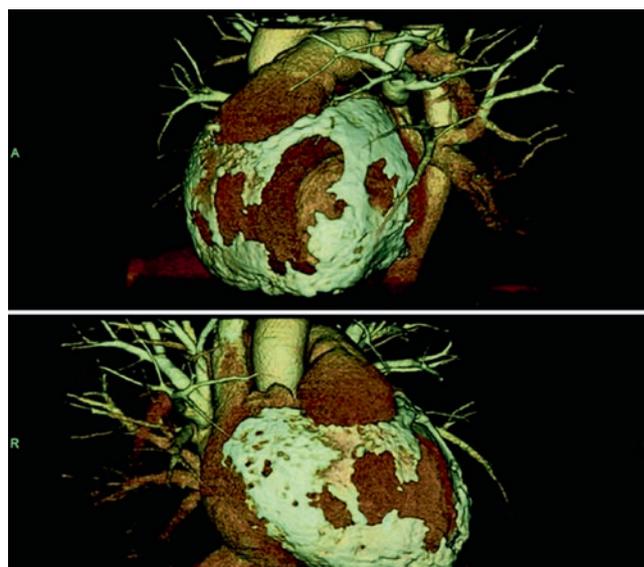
Reconstruction of a cardiac CT scan with severe calcifications over the left and right ventricles
